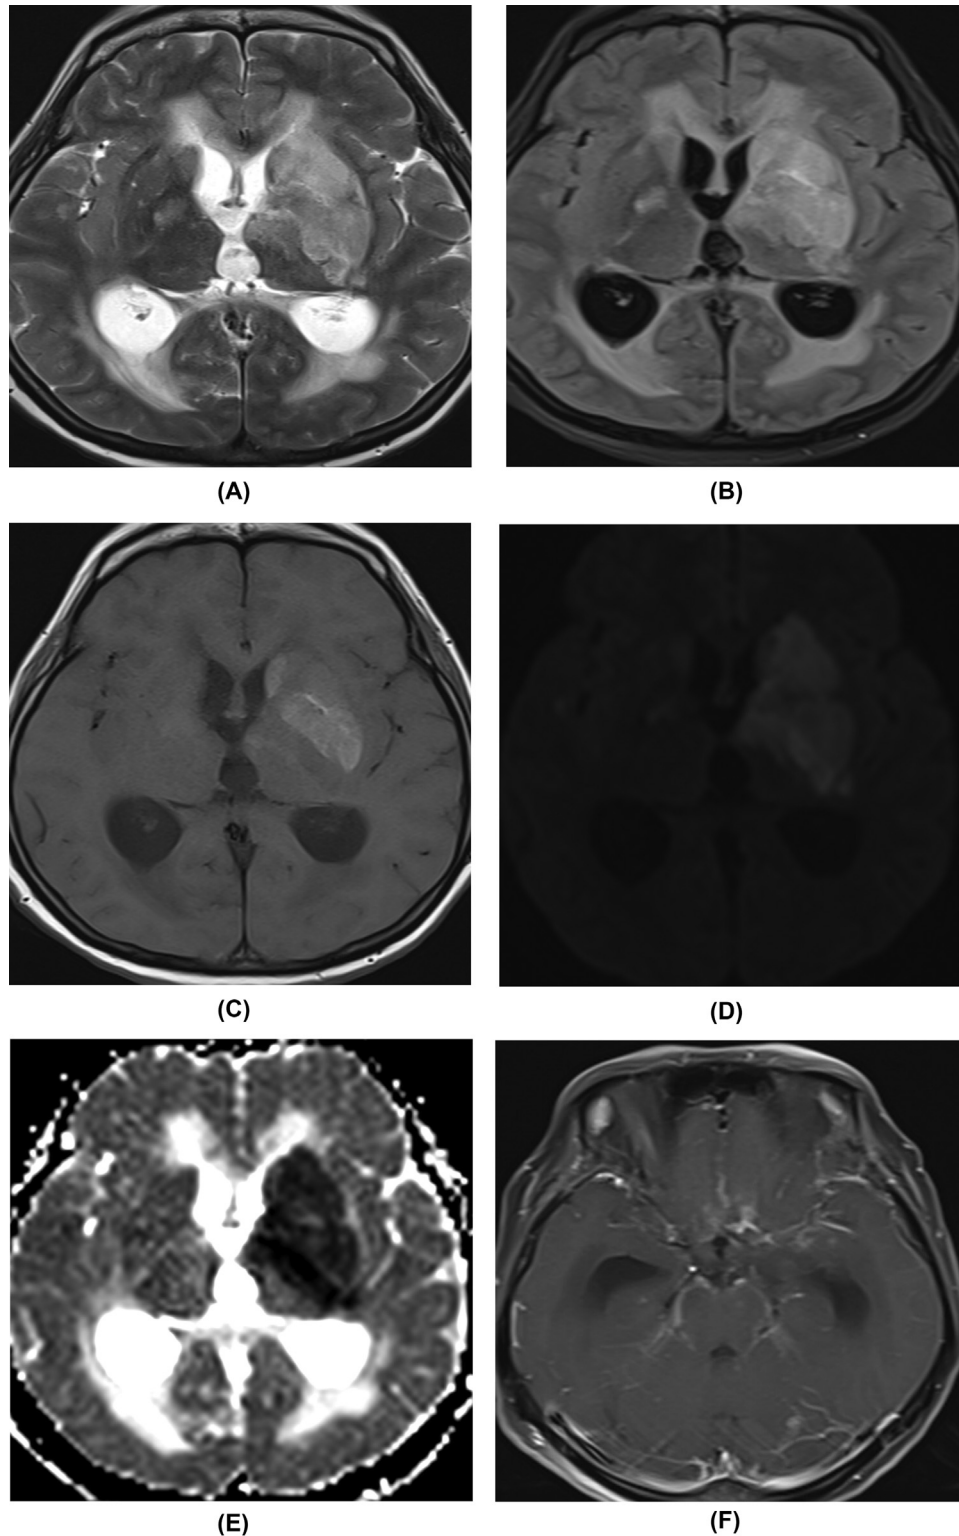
(A) T2 weighted Axial magnetic resonance Image at the level of basal ganglia showing high signal intensity in left basal ganglia, anterior and posterior limb of left internal capsule. (B) FLAIR axial magnetic resonance Image showing high signal intensity in the left basal ganglia, anterior and posterior limb of internal capsule. (C) T1 weighted axial magnetic resonance image at the level of basal ganglia showing the T1 high signal intensity within the left basal ganglia region. (D and E) DWI and ADC weighted magnetic resonance image at the level of left basal ganglia showing the diffusion restriction in left basal ganglia. (F) T1 postcontrast image at the level of basal cistern showing the patchy meningeal enhancement.
